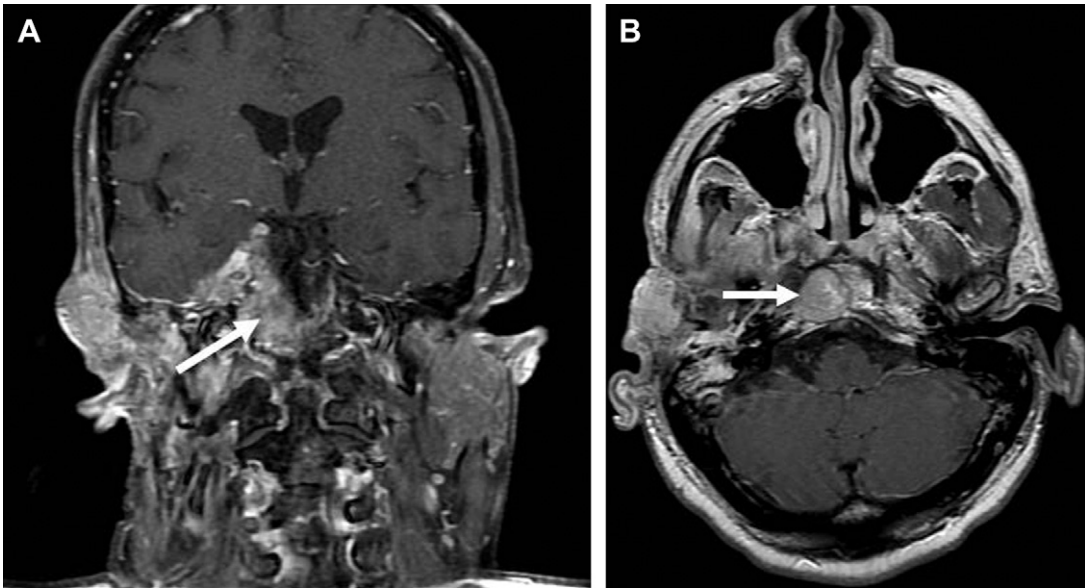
Acinic cell carcinoma, T4b from skull base involvement. (A) Coronal postcontrast fat-saturated T1-weighted image shows extensive masticator space involvement and extension to the skull base (*arrow*) and intracranially. (B) Axial postcontrast T1-weighted image with abnormal expansion and enhancement in the clivus (*arrow*).
